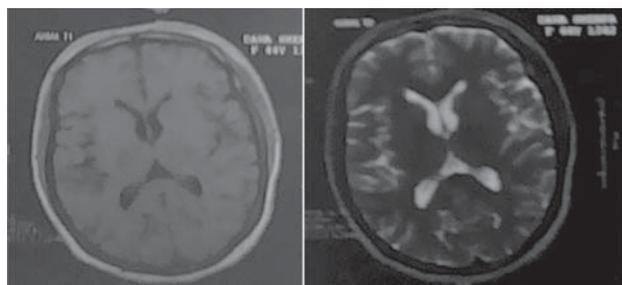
Preoperative MRI Brain, T1W and T2W Axial Images
